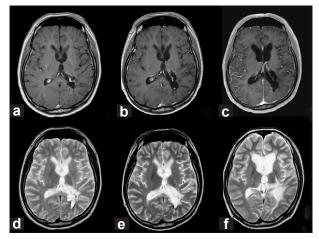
Axial views on TI-weighted images (WI) with gadolinium and T2-WI after the initial cycle of chemotherapy showing that the enhanced mass has disappeared (a and d). Follow-up MR images at 5 months (b and e) and I year (c and f) after the surgery show no evidence of recurrence. T2-WI (f) I year after the surgery shows mild ventricular dilatation and high-intensity changes in the thalamus and parietal lobe
